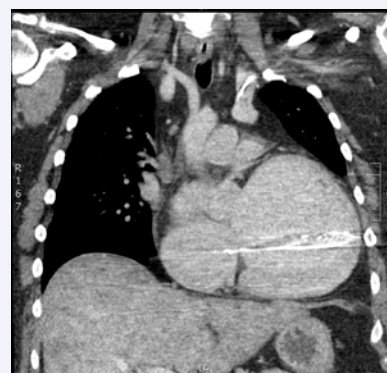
Preoperative CT scan showing persistent left sided SVC course of ICD lead beginning in the left subclavian vein and then joining the left-sided SVC.
